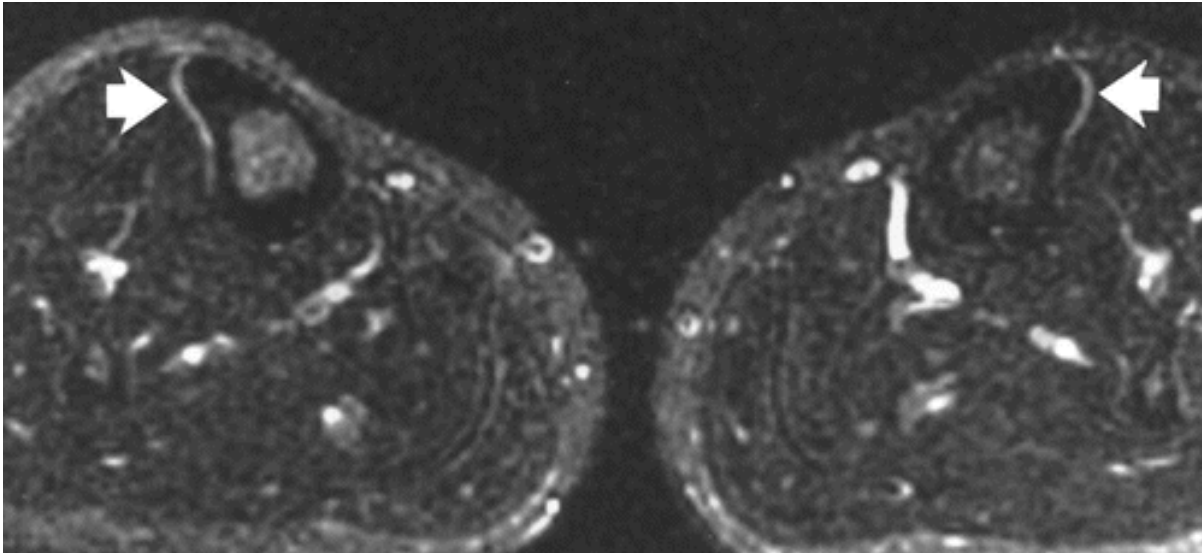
Bilateral tibial MRI with radionuclides, showing periosteal reaction (arrows) on the anterolateral border, as taken from Bergman *et al.* (2004). Note also the shape of the tibial shafts, shown here in an 18-year-old female.
